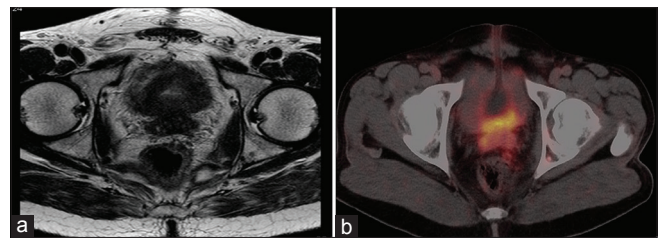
(a) Axial fat-saturated T2-weighted MR image shows hypointense prostate growth invading the bladder base as well as the seminal vesicles. (b) On axial ⁶⁸Ga-PSMA PET/CT, there is significant tracer accumulation in the bladder base and seminal vesicles, confirmative of the involvement
